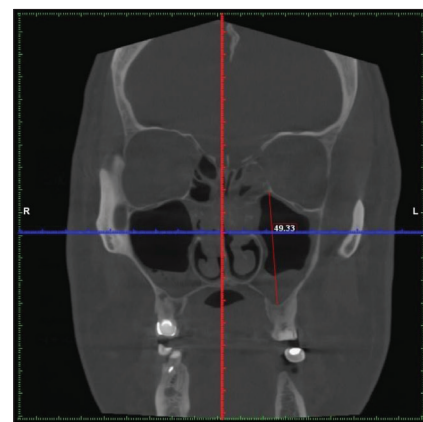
Superoinferior dimension of the maxillary sinus on coronal projection of cone-beam computed tomography
